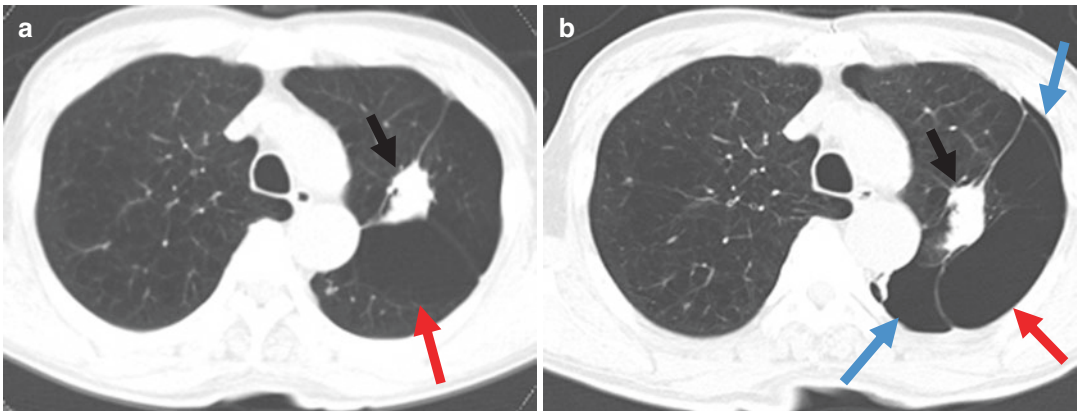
Large bullae and pneumothorax in a COPD patients. A 71-year-old male with COPD complaint of sudden dyspnea. (a) CT image at 3 month ago showed
